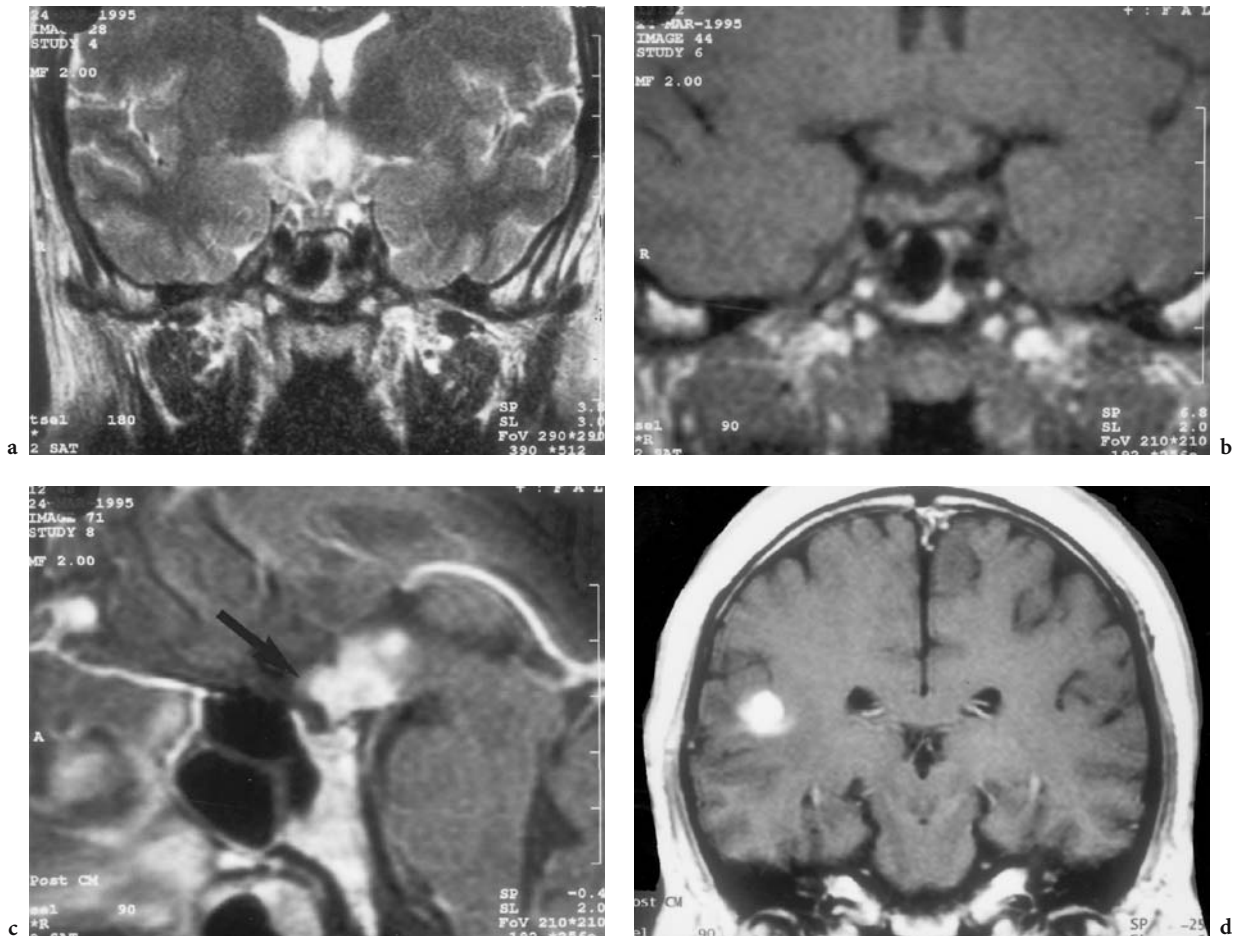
A 38-year-old man presenting with convulsions. Diagnosis on biopsy of a right temporal circumscribed focus: sarcoidosis. MRI: a Coronal T2-weighted view with hyperintensity of the chiasm and hypothalamic region. b Corresponding T1-weighted native image with undefined thickening of the chiasm. Note the small pituitary gland and short pituitary stalk. c Sagittal, T1-weighted, contrast-enhanced view showing localization of the enhancing granuloma in the hypothalamus and proximal pituitary stalk, reaching the largely unaffected chiasm (*arrow*) in the anterior part of the granuloma. d Coronal, T1-weighted, contrast-enhanced view, demonstrating the biopsied intracerebral granuloma in the posterior part of the superior temporal gyrus. (With permission of ZIR Klinikum, Ludwigshafen)
